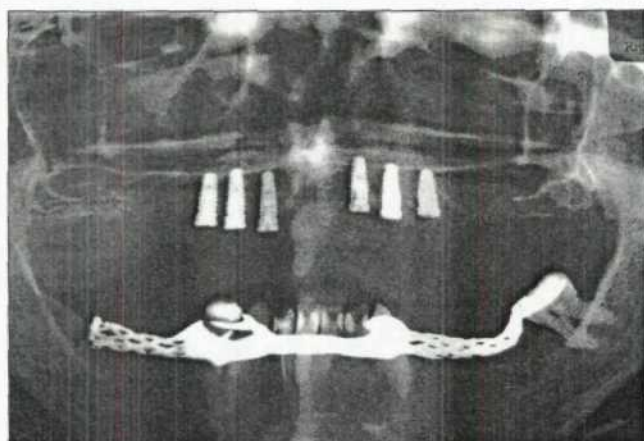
Panoramic radiograph prior to bilateral sinus graft surgery.
